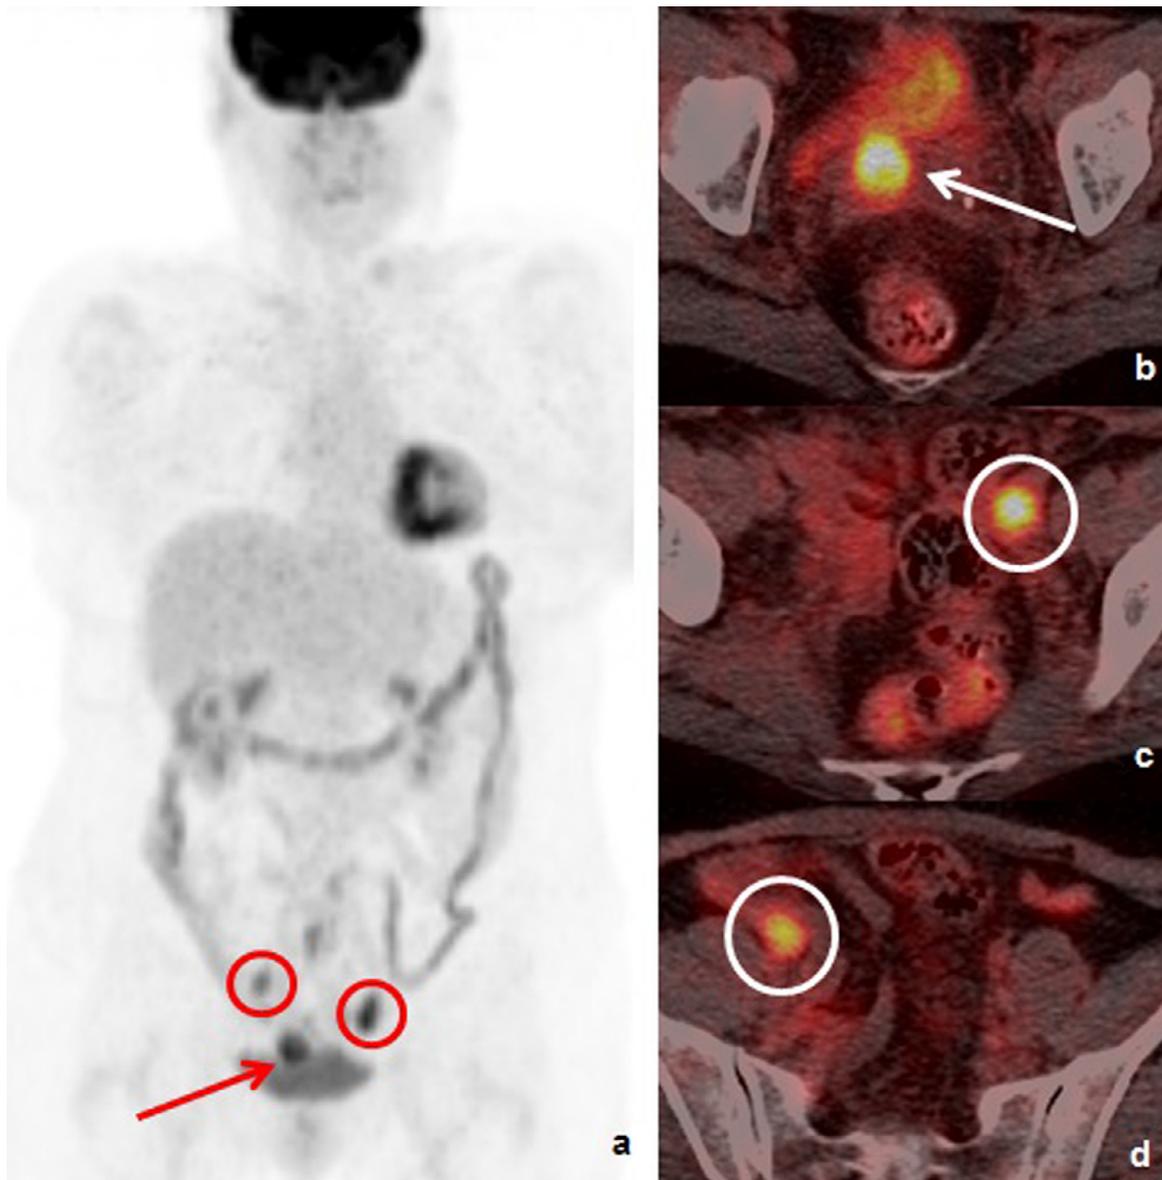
Pre-exenteration imaging: 55 year old with stage Ib1 cervical carcinoma treated with radiotherapy followed by TAH and BSO. Follow-up MRI imaging (not shown) demonstrated bulky vaginal vault recurrence. An FDG PET/CT was performed to re-stage disease and assess if suitable for exenteration. The vaginal vault recurrence (arrow) is demonstrated with bilateral pelvic lymph nodes (circles). The disease was limited to the pelvis and therefore a pelvic exenteration was performed.
